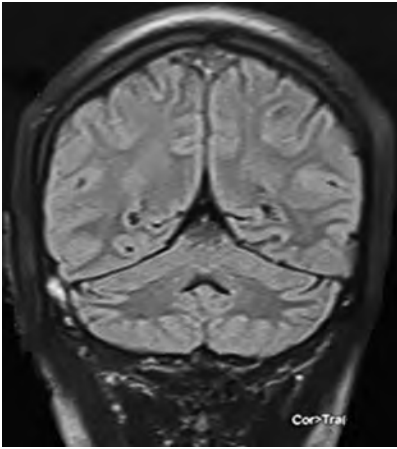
Magnetic resonance imaging (MRI) brain coronal fluid-attenuated inversion recovery image showing thrombosis of right transverse sinus and sigmoid sinus
